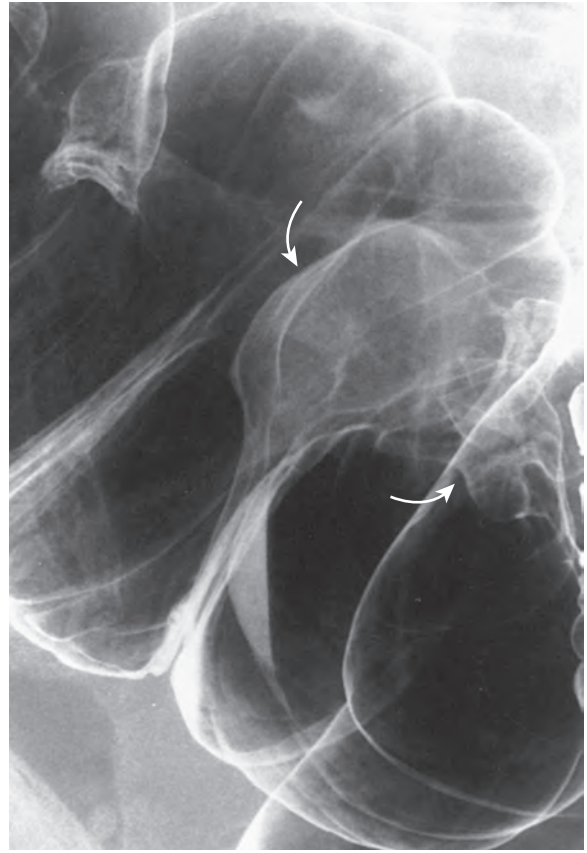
Fatty infiltration of the ileocecal valve. Close-up view from a right side-down decubitus overhead radiograph of the colon shows smooth, slightly lobulated enlargement of the ileocecal valve (arrows). Fatty infiltration was confirmed at colonoscopy performed for other reasons.
